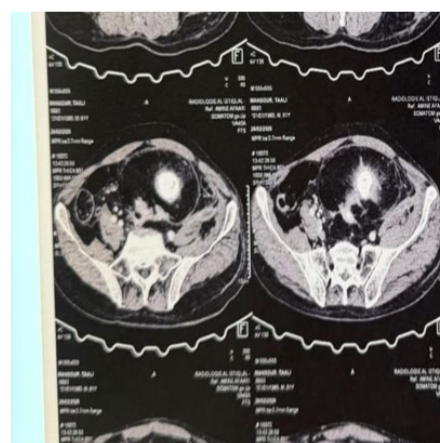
Contrast-enhanced uro-CT scan demonstrating a destroyed left pelvic ectopic kidney measuring 96 × 115 × 112 mm.
